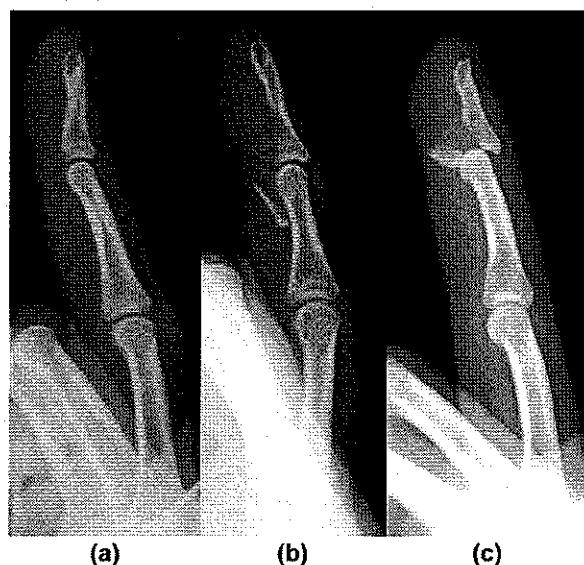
FDP avulsion fractures. (a) Type I injury without a fracture and a normal plain radiograph. (b) A significant fragment of bone is restrained by the A4 pulley (type III injury). (c) A large fracture with very little retraction (type III).
